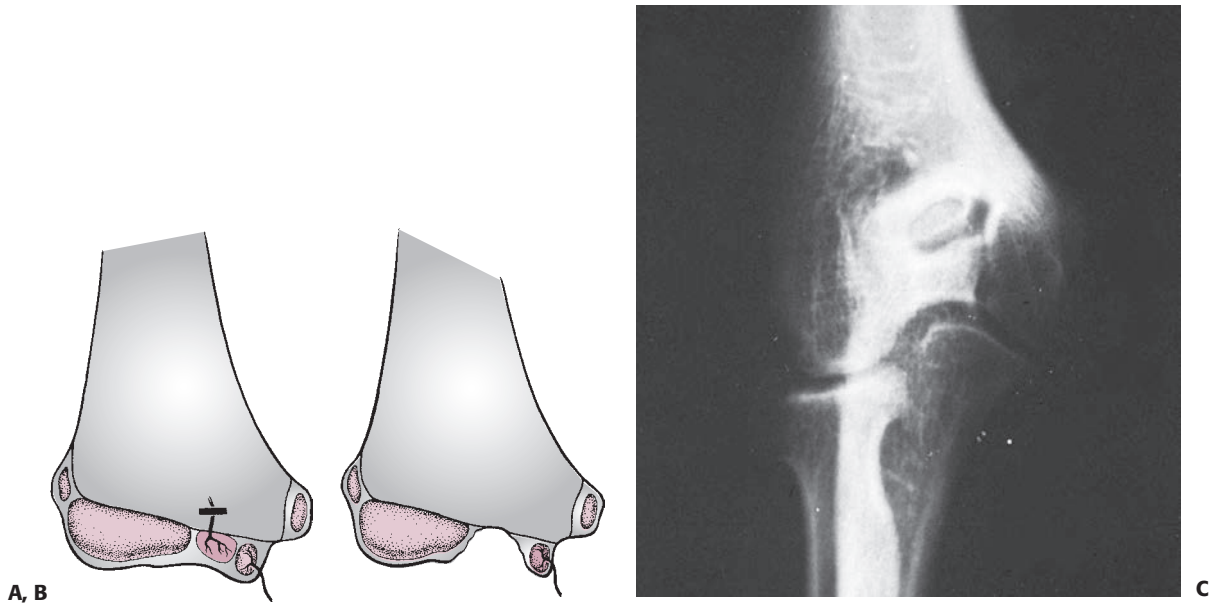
Fishtail deformity. A, B: Type A deformity. Osteonecrosis of only the lateral ossification center creates a defect in the apex of the trochlear groove. C: The typical fishtail deformity is seen in a radiograph of a 14-year-old boy who sustained an undisplaced distal supracondylar fracture 5 years previously.
